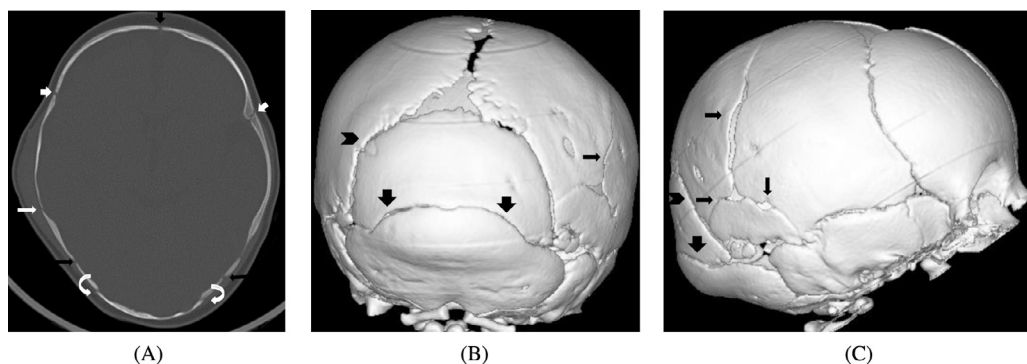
Skull fracture and sutures. (A) Axial cut from a brain CT of a 12-week-old female with history of fall and scalp swelling, demonstrates a right parietal cephalohematoma and an underlying skull fracture (long white arrow). The metopic suture (short black arrow), coronal sutures (short white arrows), and lambdoid sutures (long black arrows) can be identified. There are 2 additional lucencies (curved white arrows) in the occipital bone, which represent the bilateral mendosal sutures. (B and C) 3D reconstructed right lateral and posterior images of the skull demonstrate a right parietal fracture that branches into 2 fracture lines at its inferior aspect (thin arrows). The right lambdoid suture (arrowhead) and bilateral mendosal sutures (thick arrows) are also identified.
